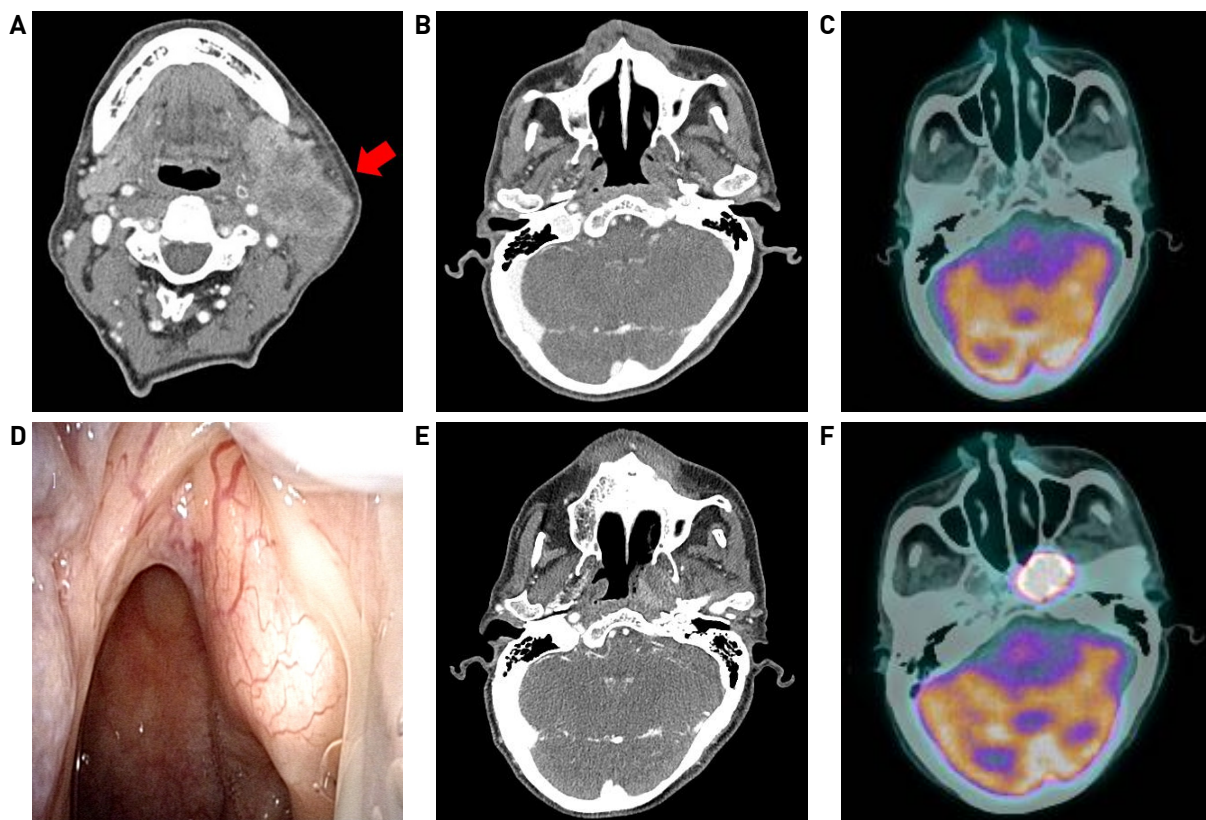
Case 2. Before detection of nasopharyngeal cancer, normal CT on the nasopharynx(A) and left metastatic neck mass(B) and normal PET-CT image on nasopharynx(C). After detection of left nasopharynx cancer, endoscopic finding of left nasopharyngeal cancer(D), left nasopharyngeal mass on CT(E) and PET-CT(F) images.
